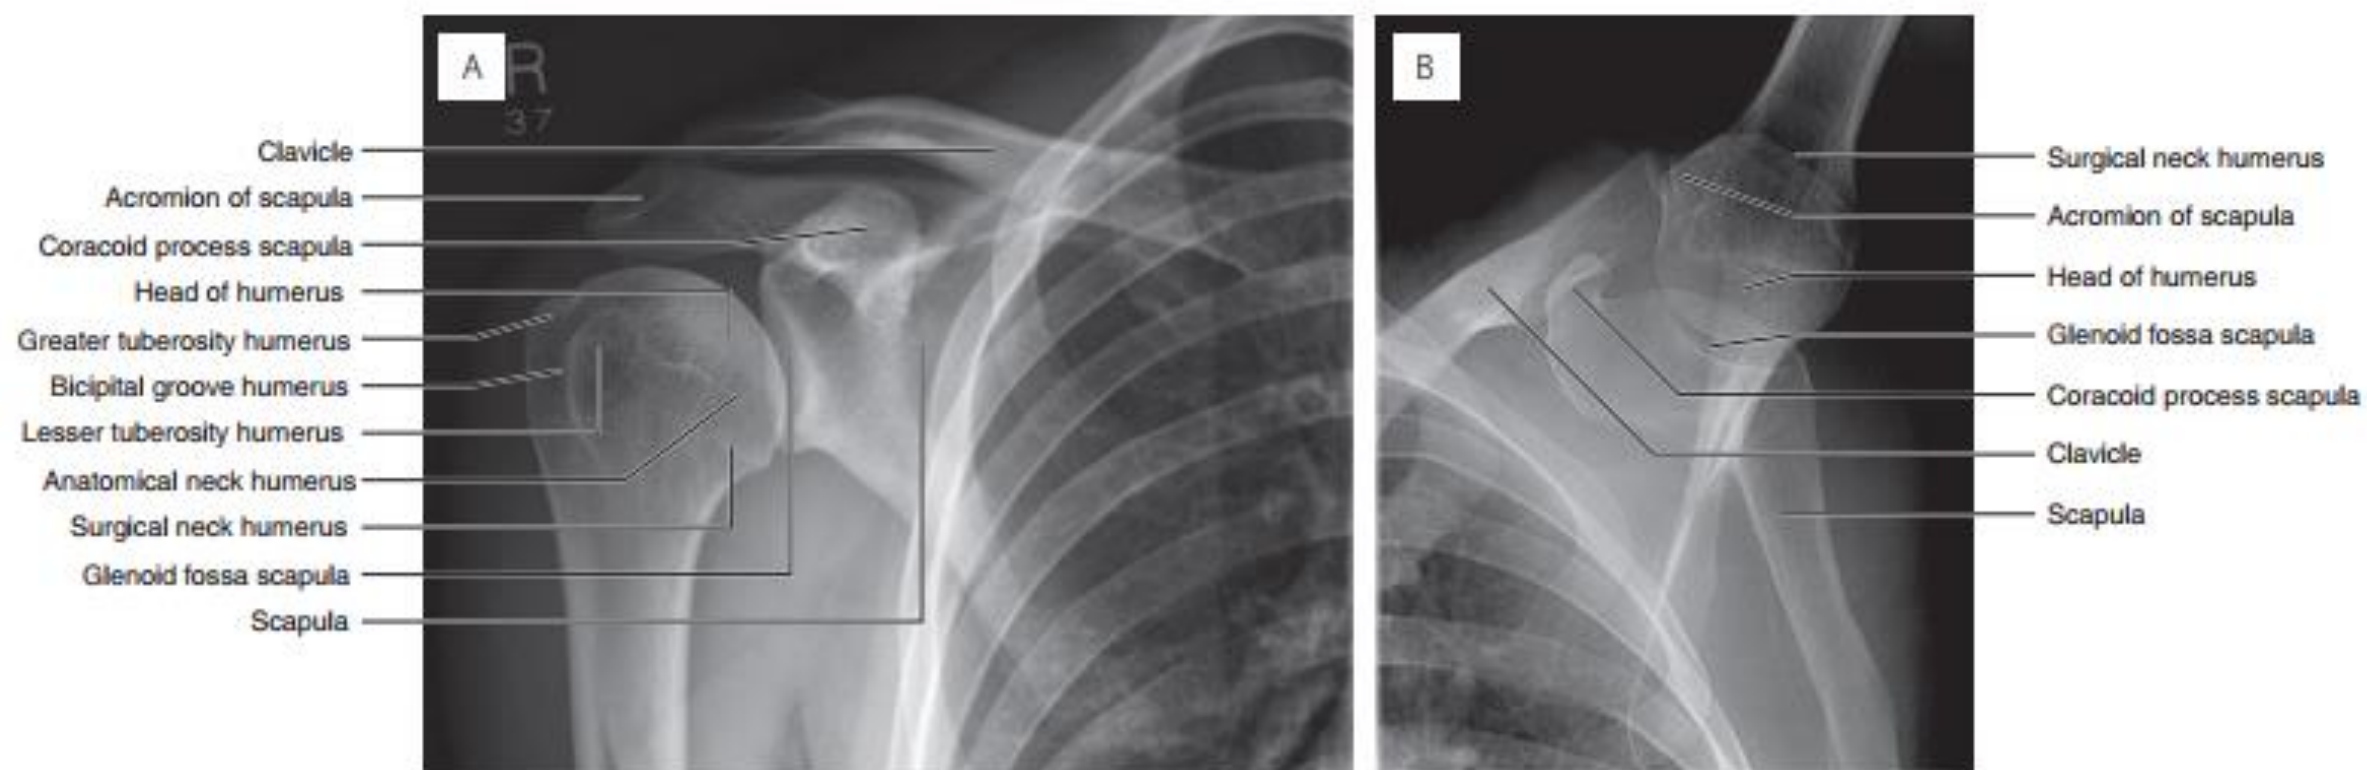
(A) AP radiograph of the right shoulder and (B) axial radiograph of the right shoulder.
